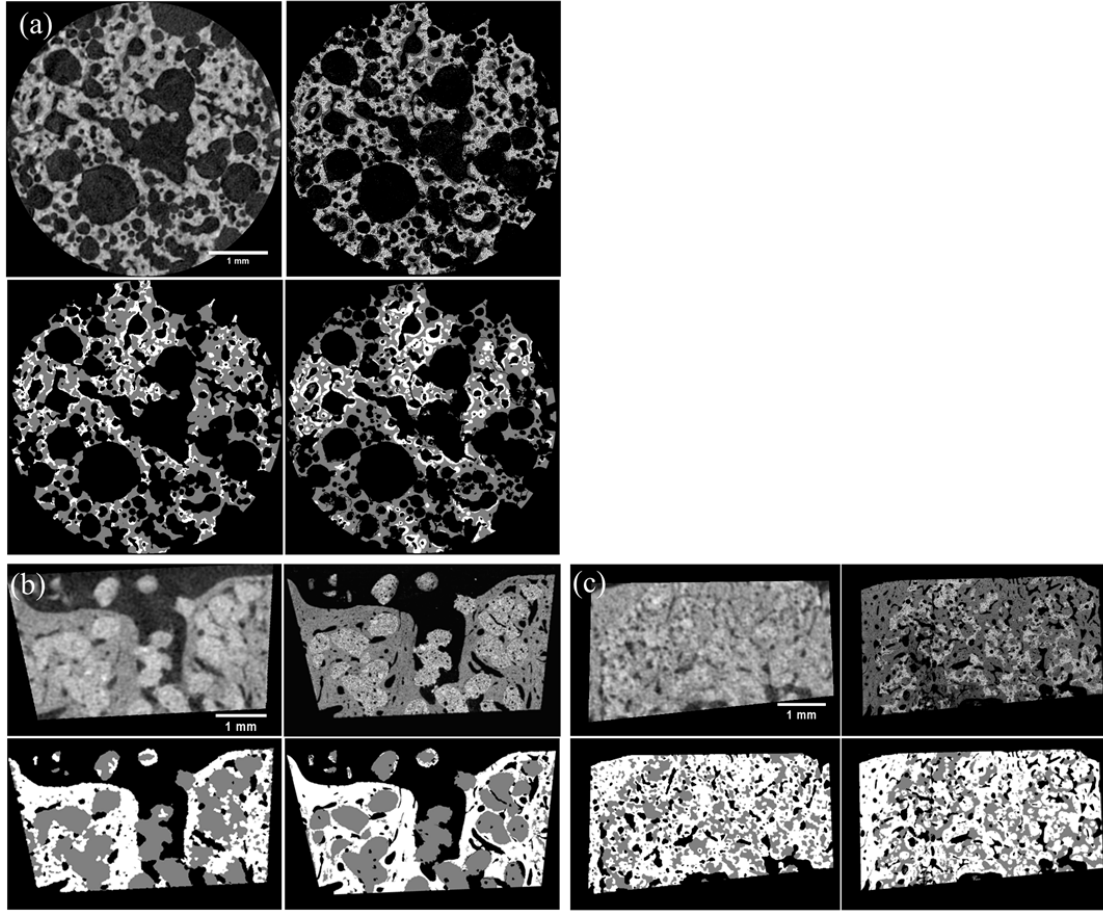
Representative μ CT cross-sections (left) and corresponding SEM images (right) after 12 weeks; one IM foamed sample (a), one IO robocast sample (b) and one IO foamed sample (c). Below the μ CT and SEM images are the respective segmented images with bone in white and remaining scaffold in gray. The images were segmented using Method 3.
